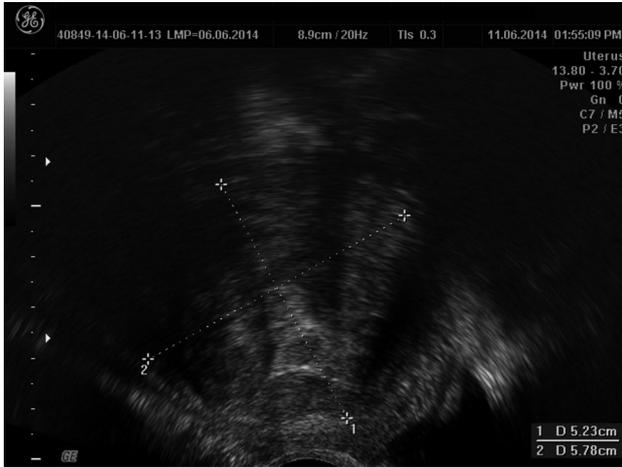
Image of 2D ultrasound in the uterine PEComa (before first intervention).
